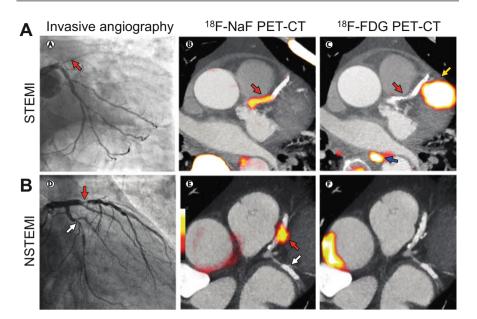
(a) PET-CT of a patient with acute ST-segment elevation myocardial infarction with proximal occlusion of the left anterior descending artery on invasive coronary angiography and intense focal 18F-fluoride uptake at the site of the culprit plaque but in remote myocardium. The corresponding 18F-fluorodeoxyglucose PET-CT image shows no uptake at the site of the culprit plaque. (b) Example of a patient with anterior non-ST-segment elevation myocardial infarction with a culprit lesion (*red arrow*) and bystander non-culprit lesion demonstrates that only the culprit lesion had increased 18F-NaF uptake on PET-CT; the corresponding 18F-fluorodeoxyglucose PET-CT shows no uptake at either the culprit or the bystander stented lesion
